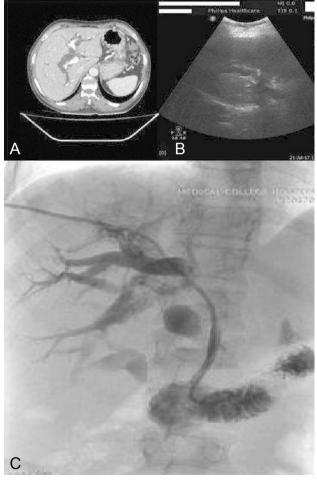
(A,B,C): Case showing dilated biliary radicles in CECT, pre-puncture Ultrasound and finally placement of PTBD catheter. (IED done)
